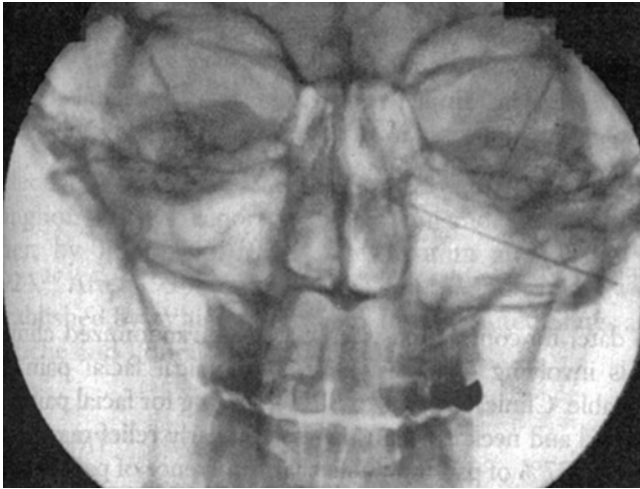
The radiographic anteroposterior view of the face shows the needle tip at the lateral wall of the nose at the superomedial angle of the maxillary sinus (Raj Interventional Pain Management Image-Guided Procedures)
